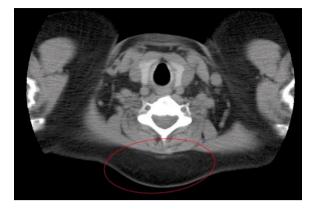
Tumor has unclear boundaries with the surrounding tissues. Unenhanced CT shows a lipoma of the upper back. The boundaries between the tumor and the surrounding tissues (inside the red ellipse) are unclear
